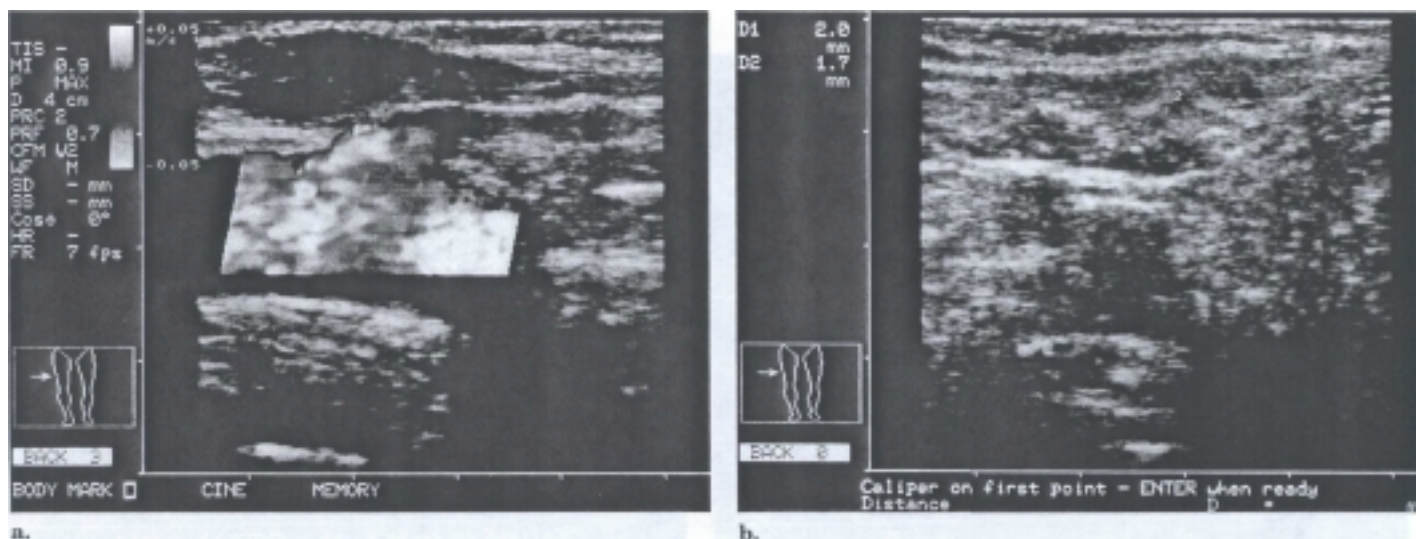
Six-month follow-up color Doppler examination demonstrating (a) absence of flow within the treated GSV segment (longitudinal view) and (b) significant reduction in GSV diameter, now measuring 2.0 mm X 1.7 mm in the transverse dimension.
